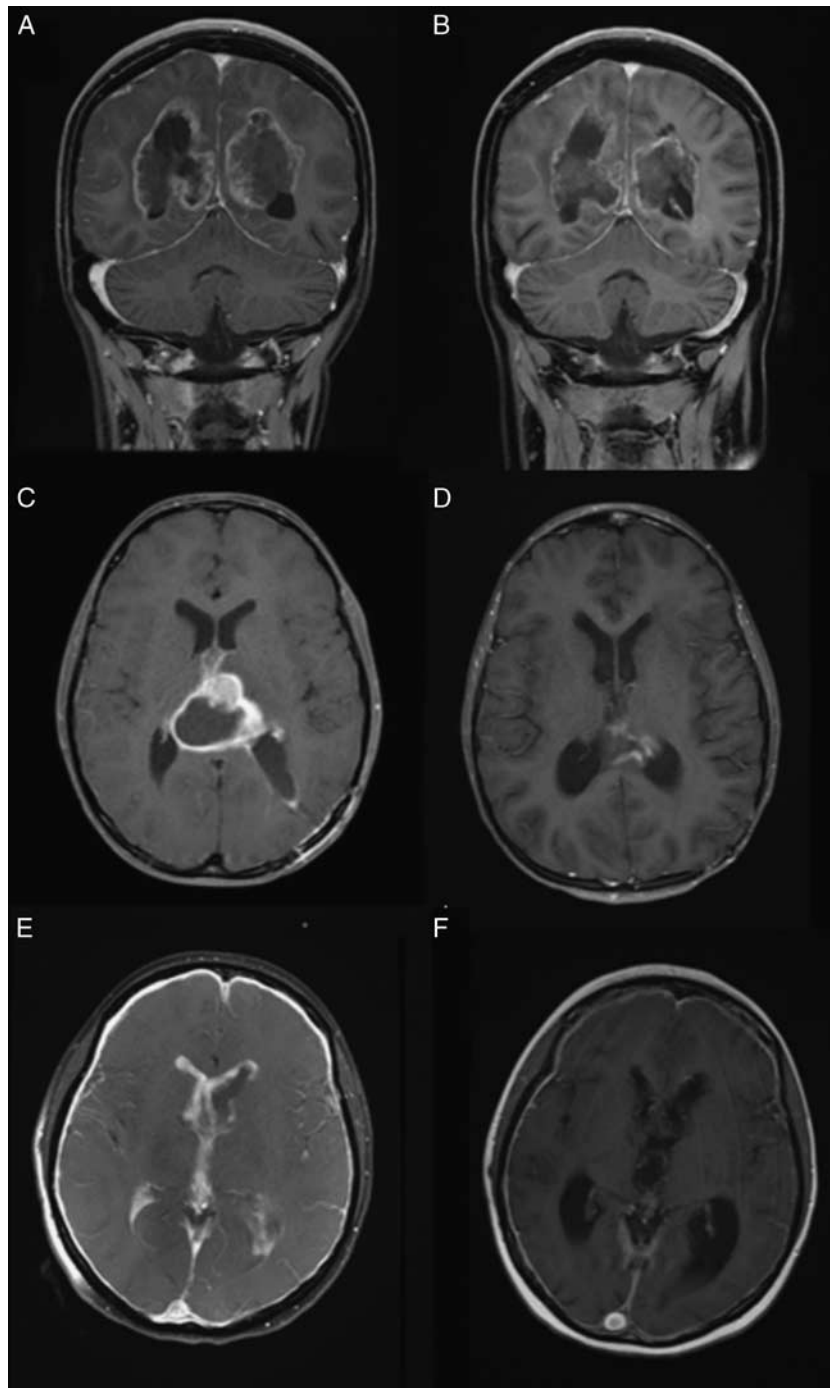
T1-Post Gadolinium MRI before and after nivolumab treatment. A, Prenivolumab brain MRI for patient 1; B, decreased disease burden post nivolumab. C, Prenivolumab brain MRI for patient 4; D, shrinking tumor size postnivolumab. E, Prenivolumab brain MRI for patient 3; F, decreased leptomeningeal and ependymal enhancement postnivolumab treatment.
